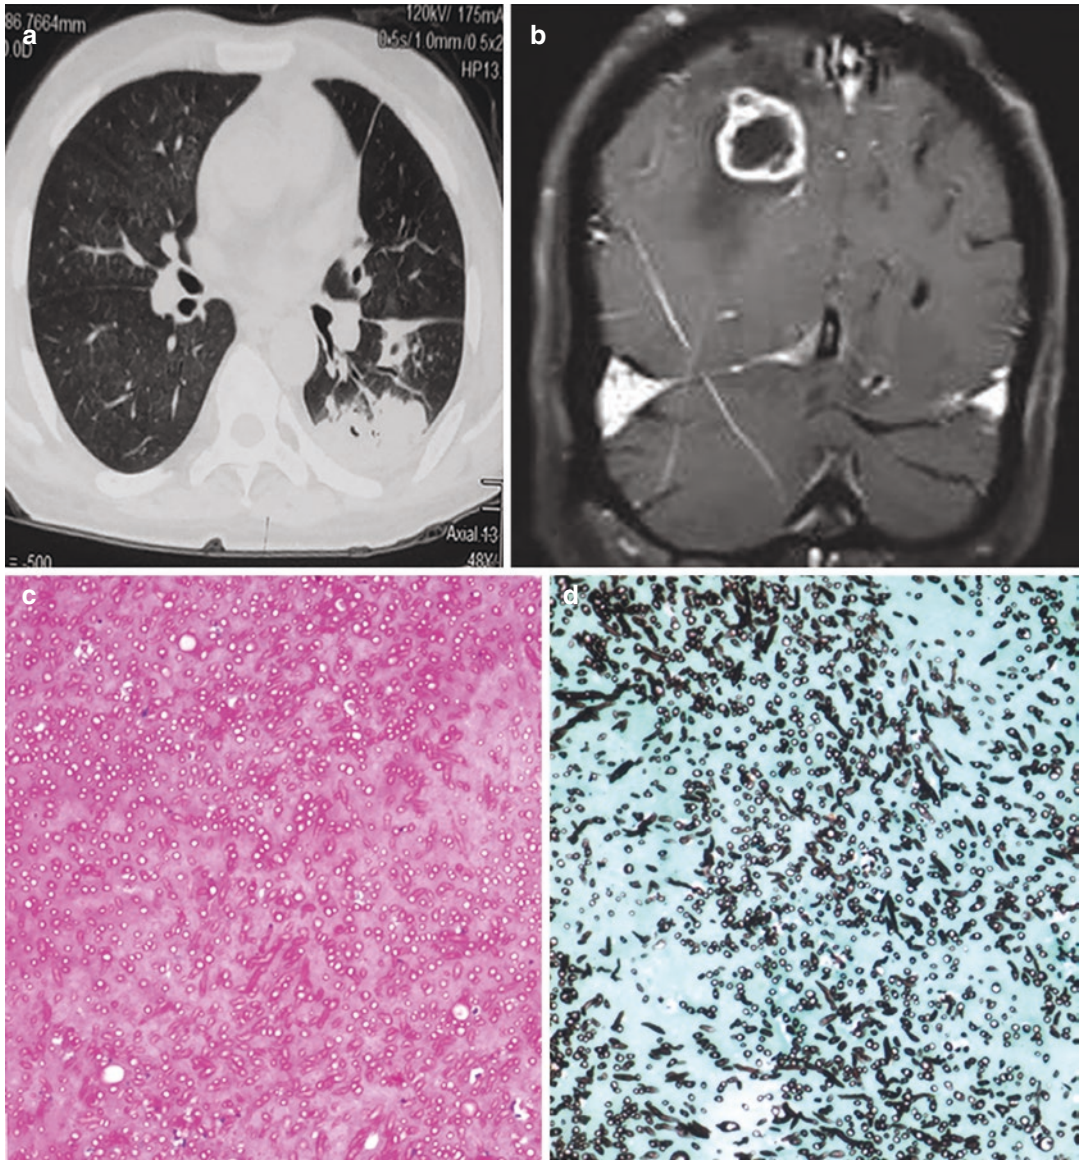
(a) Arrow points to the ill-defined nodular opacities in the chest tomograms; (b) Magnetic resonance imaging, brain showing peripheral ring-enhancing lesions
